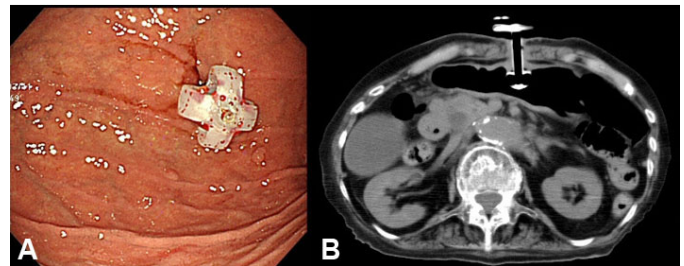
Gastroendoscopy nine months prior to the patient's current complaints. The PEG tube was placed via the anterior wall of the stomach at our hospital. (A) Gastroendoscopy and (B) Computed tomography.
